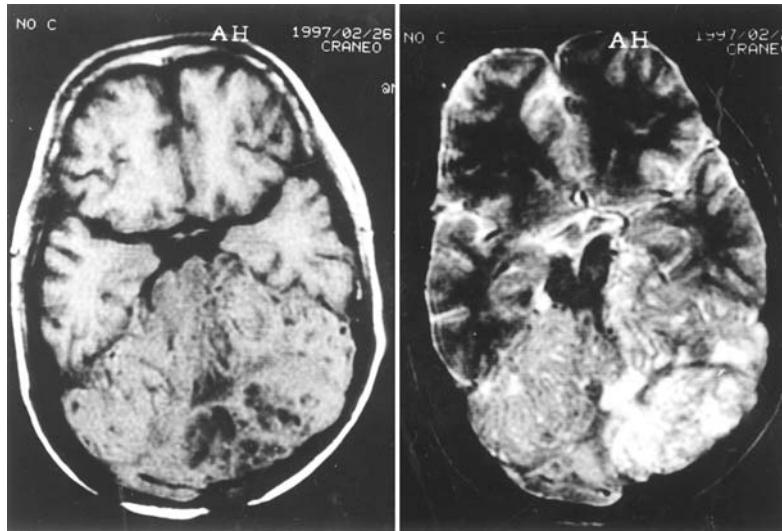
Case no 3: MRI study shows the typical picture of Lhermitte-Duclos disease. Both cerebellar hemispheres are entirely involved. Left: T1 sequence, right: T2 sequence. Severe enlargement and distortion of posterior fossa with obliteration of the fourth ventricle and compression of the brain stem can be appreciated
